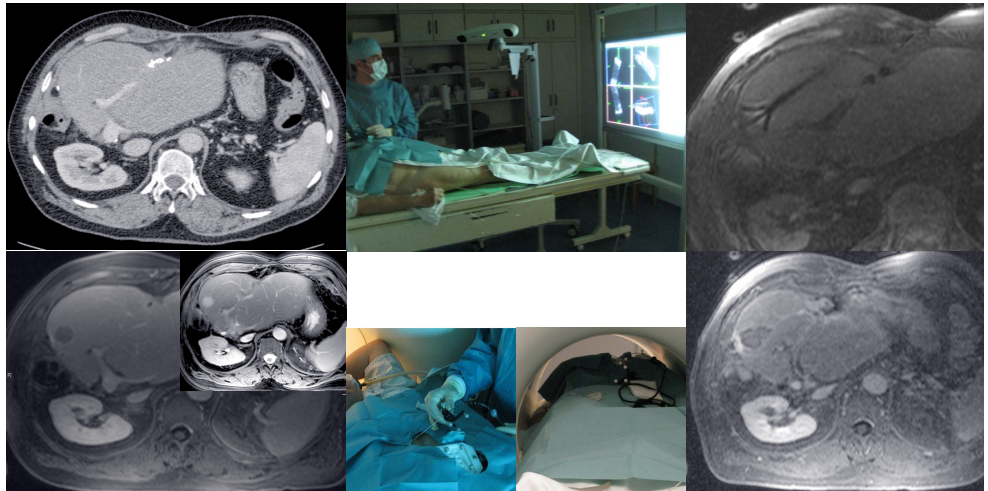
Top: Post contrast CT image in portal venous phase; the tumor can not be delineated. Bottom: T1-weighted VIBE image post contrast (Gd-EOB-DTPA); hypointense tumor can be delineated. Small inset shows hyperintense tumor region on T2-weighted image.
